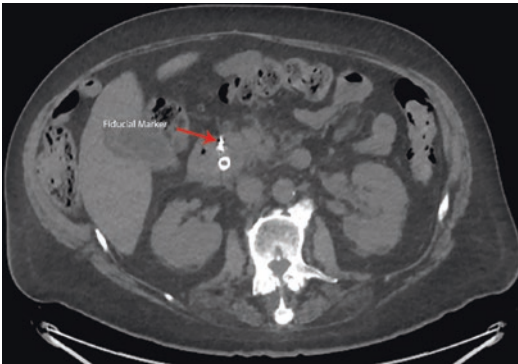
Fiducial marker shown within the pancreatic tumor on CT-scan next to a biliary stent to help guide radiation treatment with SBRT
